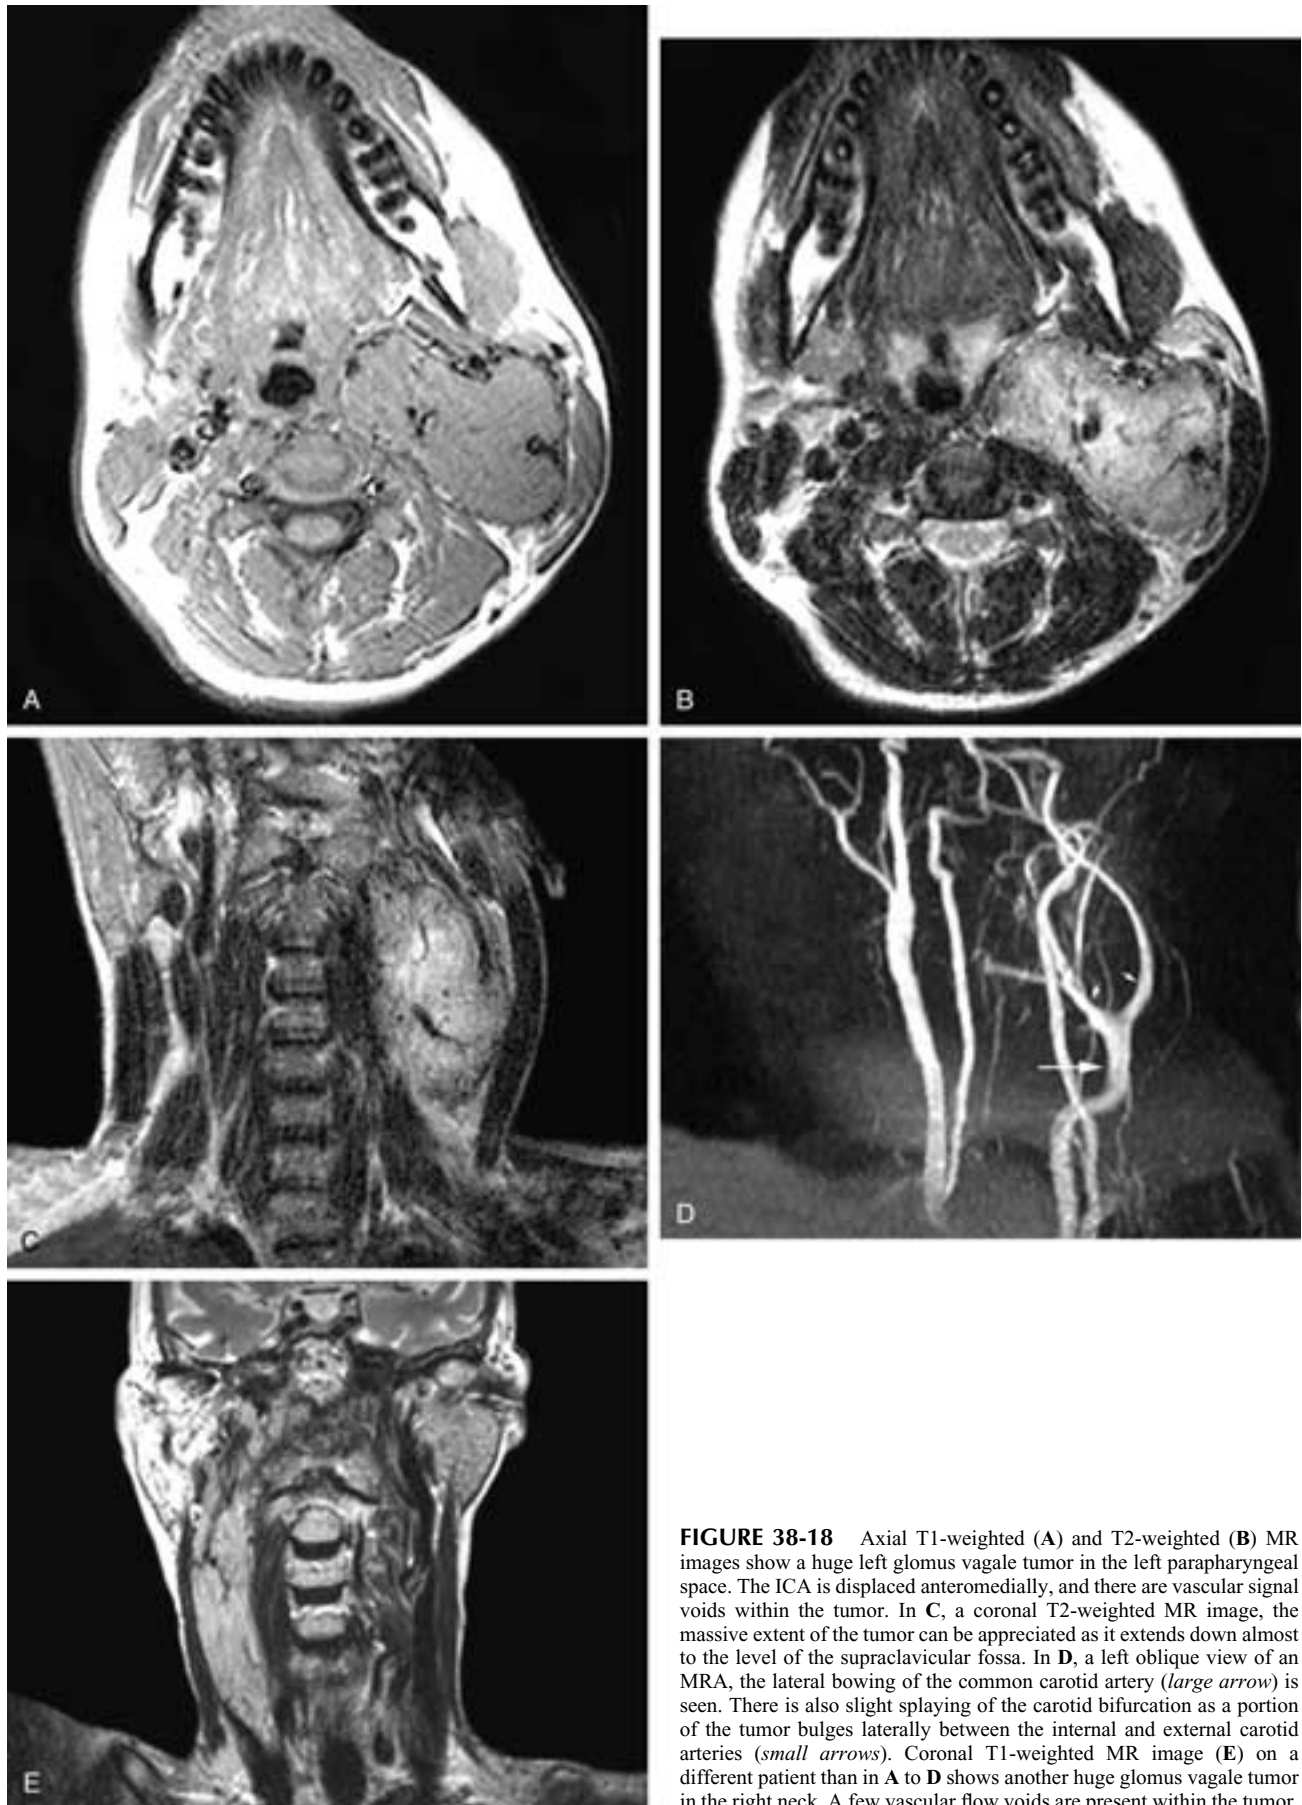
Axial T1-weighted (A) and T2-weighted (B) MR images show a huge left glomus vagale tumor in the left parapharyngeal space. The ICA is displaced anteromedially, and there are vascular signal voids within the tumor. In C, a coronal T2-weighted MR image, the massive extent of the tumor can be appreciated as it extends down almost to the level of the supraclavicular fossa. In D, a left oblique view of an MRA, the lateral bowing of the common carotid artery (*large arrow*) is seen. There is also slight splaying of the carotid bifurcation as a portion of the tumor bulges laterally between the internal and external carotid arteries (*small arrows*). Coronal T1-weighted MR image (E) on a different patient than in A to D shows another huge glomus vagale tumor in the right neck. A few vascular flow voids are present within the tumor.
